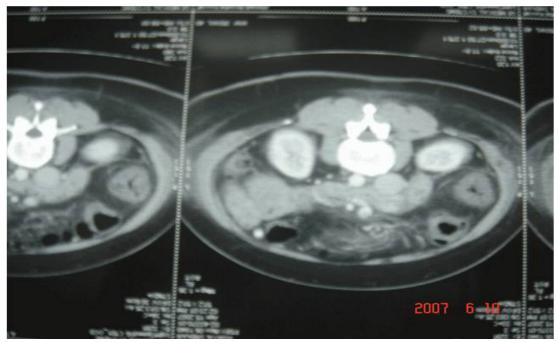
CT Abdomen showing Paraumbilical venous shunt
